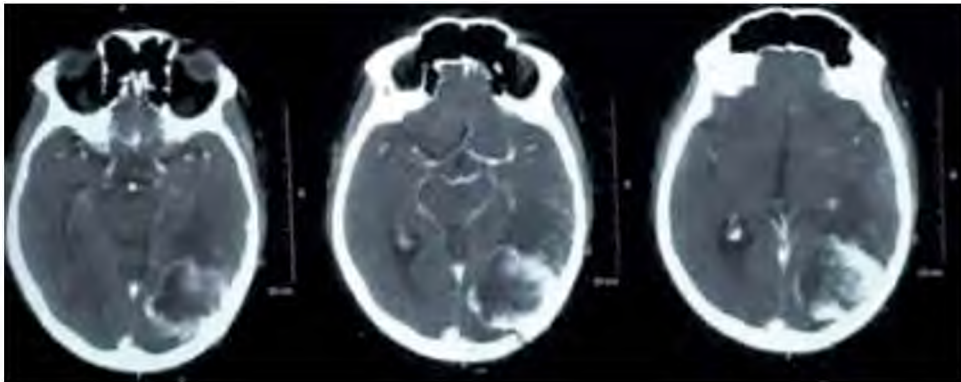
Case (1) Preoperative CT brain with contrast showing left occipital metastasis.
